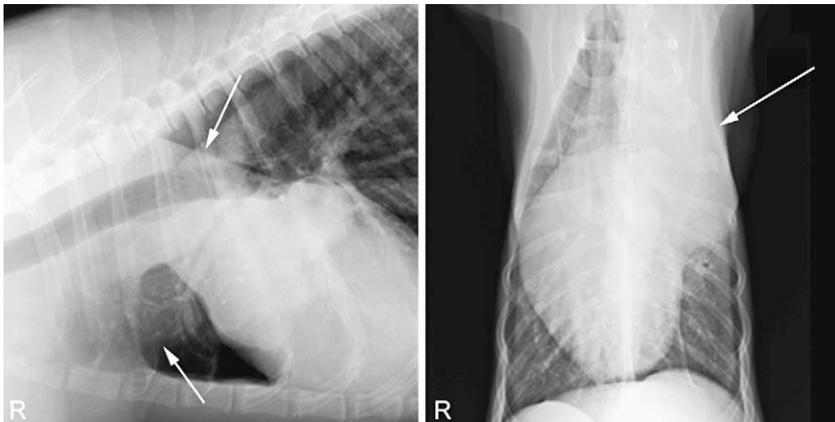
Orthogonal thoracic radiographs of a 10-year-old, neutered female greyhound with a consolidated cranial part of the left-cranial lung lobe (*arrows*). Note that the abnormal lung lobe is fully expanded and enlarged, displacing the heart away from the abnormal lung lobe (to the *right*).
